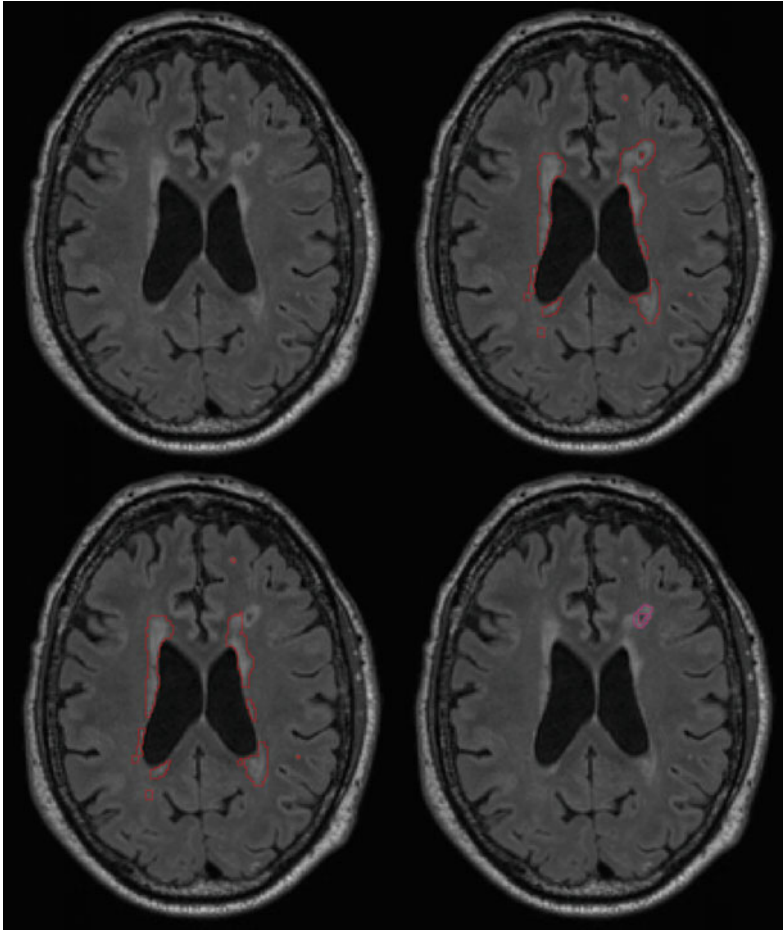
FLAIR MRI from a patient with ischaemic stroke presenting with WMH and a lacune of presumed vascular origin (top left panel). Quantitative assessment initially defined the rim of the lacune as a WMH (red outline top
